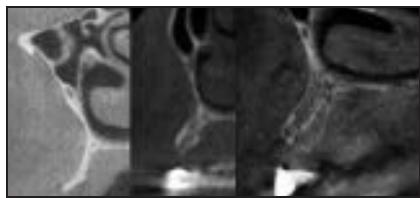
Cone beam computed tomography (CBCT) cross-sectional imaging of maxillary right first premolar site at (left) initial examination, (center) 6 months after corticocancellous bone grafting, and (right) 6 months post-tissue engineering via rhBMP-2/ACS + cancellous allograft.
